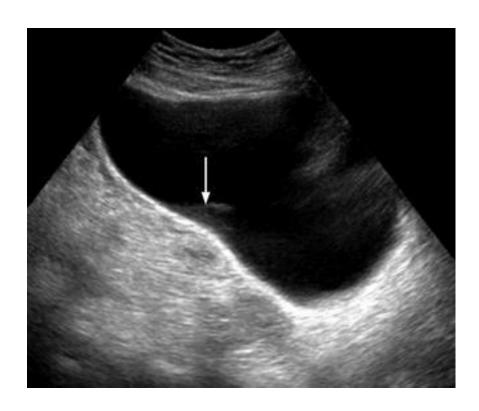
Beam width artifact. (a) The ultrasound image localization software assumes an imaging plane as indicated by the dotted lines. (b) Echoes generated by the object located in the peripheral field (gray circle) are displayed as overlapping the object of interest (white square). (c, d) Adjusting the focal zone and placing the object of interest within the center of the focal zone (c) will eliminate the misplaced echoes on the display (d). (e) Longitudinal US image of a partially filled bladder shows echoes (arrow) in the expected anechoic urine. The focal zone is improperly set too shallow. (f) Longitudinal US image obtained after adjustment of the focal zone and optimal placement of the transducer shows resolution of the intravesical echoes.
